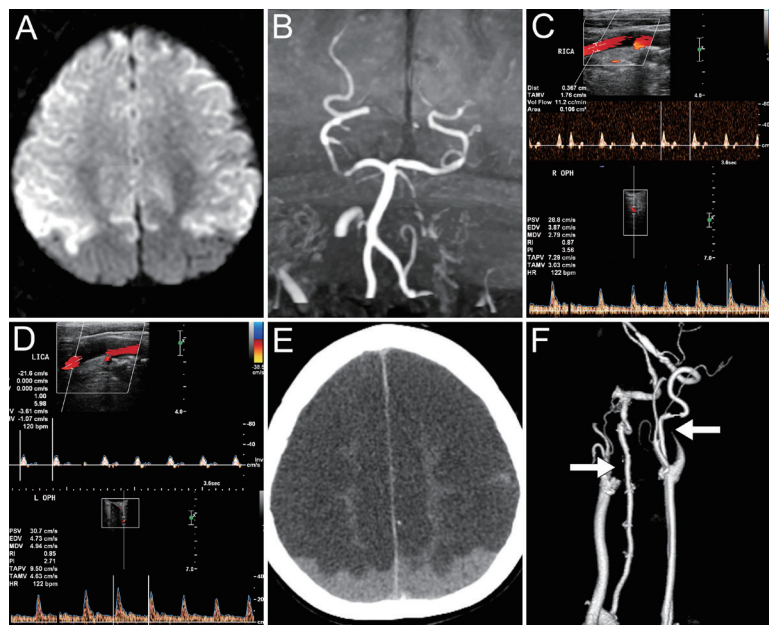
Imaging studies of patient 4 with acute bilateral ICA occlusion. (A) Axial view of diffusion-weighted MRI findings on day 1 indicated acute infarction involving both frontoparietal lobes. (B) MRA revealed absent bilateral ICAs. (C and D) CDS on day 2 showed patent bilateral proximal ICAs with extremely highly resistant flow (upper half) and forward bilateral OAF (lower half). (E) Axial brain CT on day 3 revealed acute infarction with diffuse edematous change involving both frontoparietal lobes. (F) Brain CTA on day 3 showed occlusion of the bilateral proximal ICAs (arrows).
